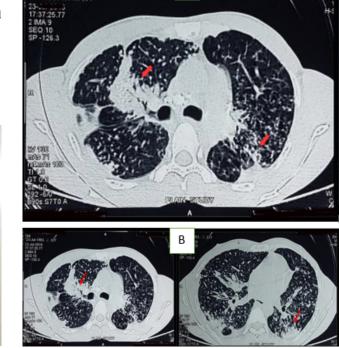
A&B: HRCT thorax showing multiple subpleural and centrilobular nodules in bilateral upper, lower lobes and right middle lobe and progressive massive fibrosis there is also bronchial dilatation and fibrosis
